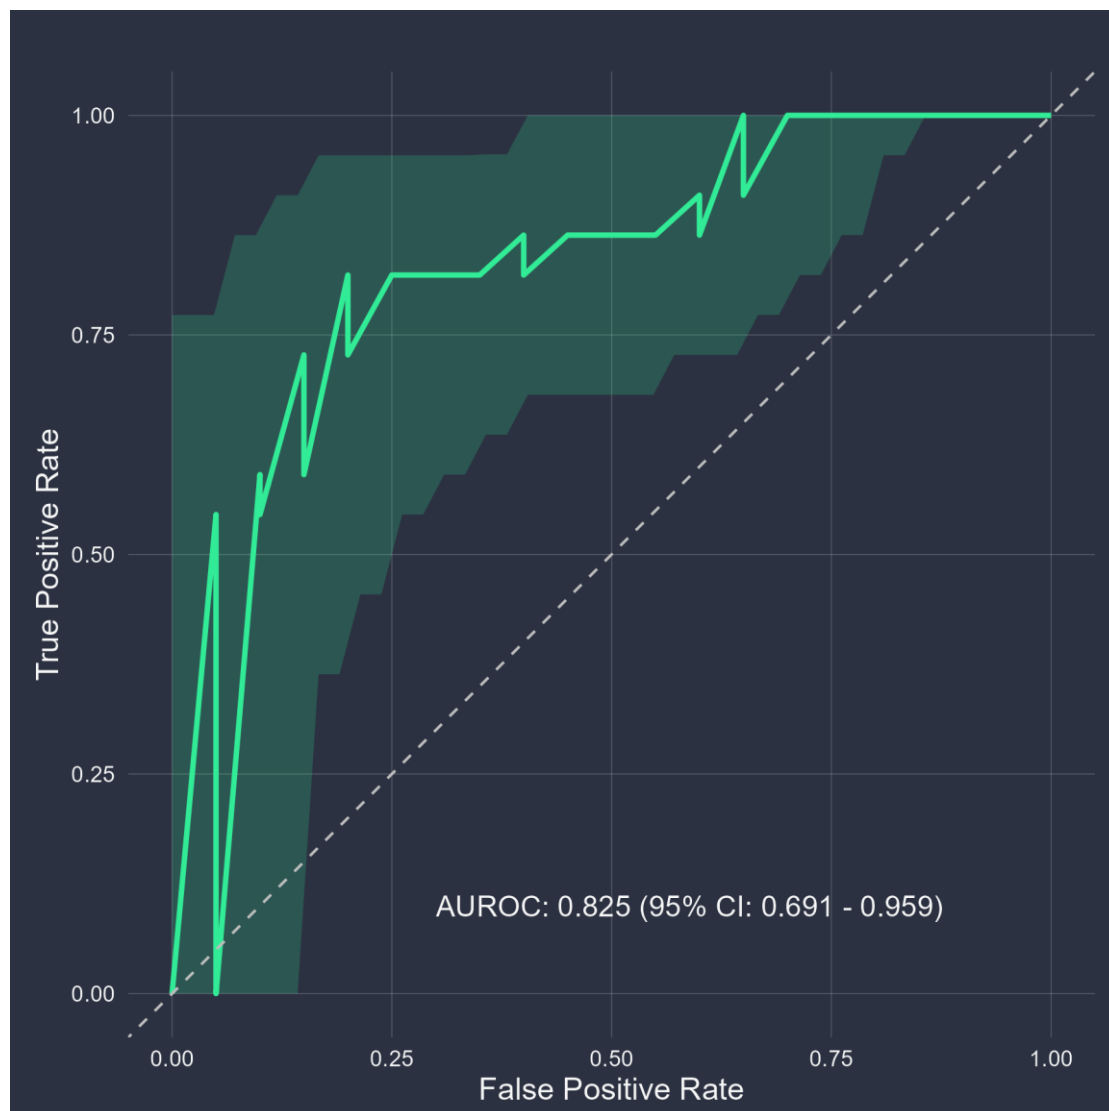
Receiver Operating Curve and associated AUROC with 95% confidence intervals for the radiograph-based AI algorithm.
